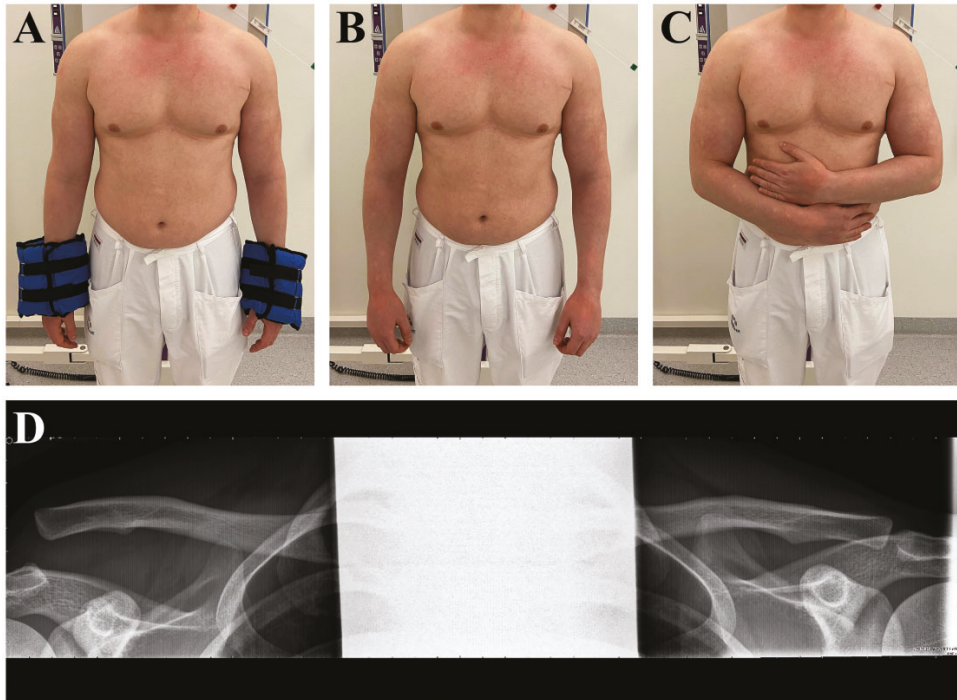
Photographs showing patient positioning for the weighted (a), non-weighted (b), and internal rotation (c) panorama radiographs. Example non-weighted radiograph (d).
